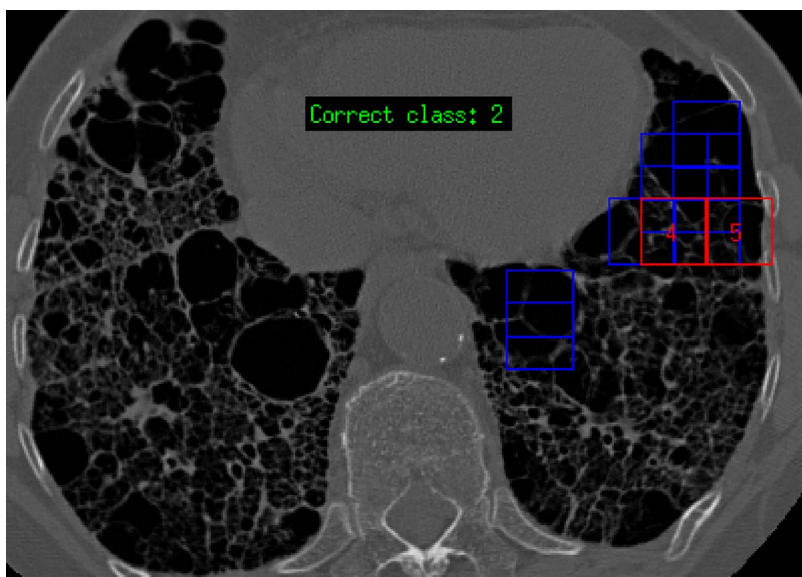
Typical misclassifications of HRCT regions from the ILD database are shown here. They occur often at the boundary of the annotated region. Emphysema was wrongly classified as fibrosis and micronodules.
